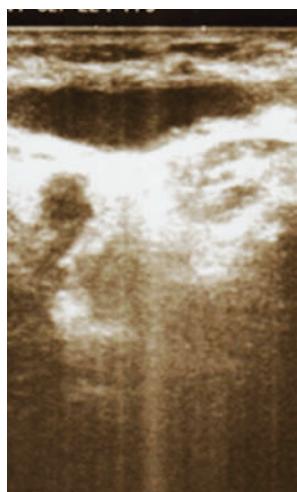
Showing lesional ultrasound examination with no evidence of mycetoma but multiple dilated, compressible vessels with a venous flow profile on doppler ultrasound examination.
